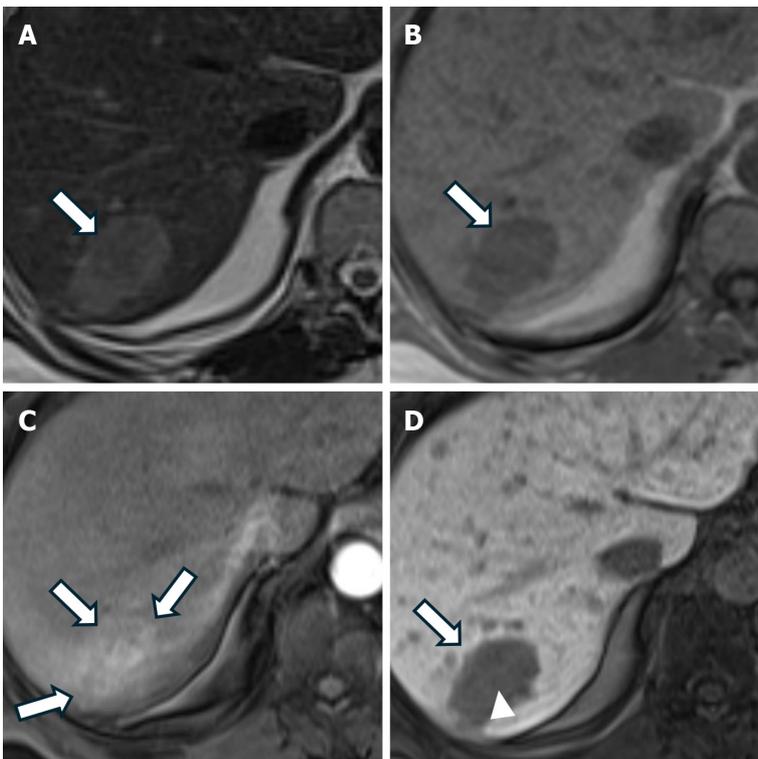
Hepatocellular carcinoma in a 53-year-old man with chronic hepatitis B infection. A: Axial T2 weighted magnetic resonance imaging (MRI) shows a T2 mildly hyperintense lesion (arrow); B: Axial T1 weighted MRI image shows a T1 hypointense lesion (arrow); C: Axial post-contrast T1 weighted MRI with a hepatobiliary-specific contrast agent in the arterial phase shows an enhancing lesion (arrows); D: Axial post-contrast T1 weighted MRI in the hepatobiliary phase shows a lesion (arrow) with a washout (arrowhead).
